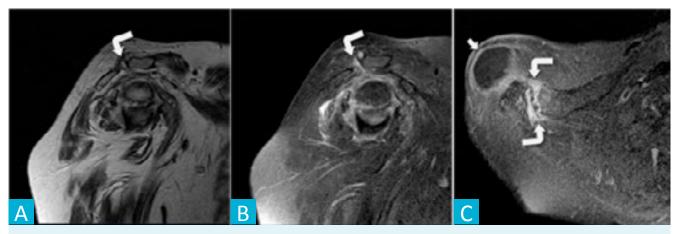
Pseudo-geyser. Sagital T1w (A), sagital T2w fat-saturated (B) and axial T1w fat-saturated after intravascular gadolinium (C) MR images depicting the acromioclavicular joint [curved arrow] with some degenerative changes, effusion and periarticular edema but with no relationship to the pseudo-geyser [arrow].
